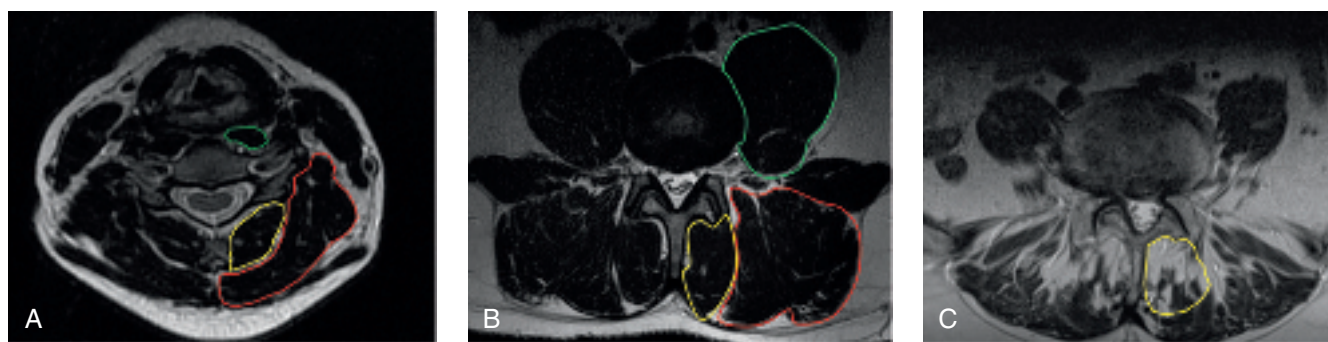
Axial T2-weighted magnetic resonance images of (A) normal midcervical spine musculature demonstrating the anterior flexor longus colli (green), the deep extensors semispinalis cervicis and multifidus (yellow), the superficial extensors semispinalis capitis, splenius capitis and longissimus (red); (B) normal lumbar spine musculature at the L4-L5 disk space demonstrating the psoas (green), the deep extensor, multifidus (yellow), and superficial erector spinae (red); and (C) the lumbar spine musculature after open decompression demonstrating significant fatty atrophy of the multifidus muscle (yellow).
